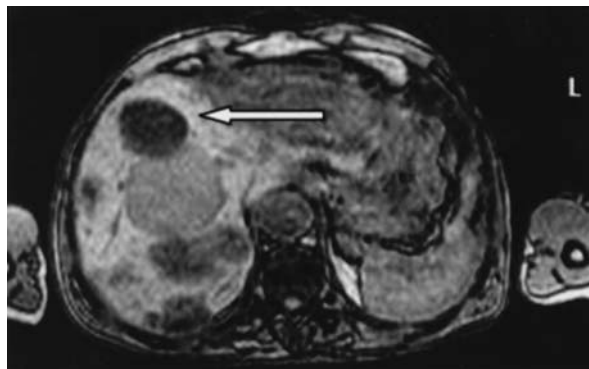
Magnetic resonance imaging of the bleeding lesion of the liver
